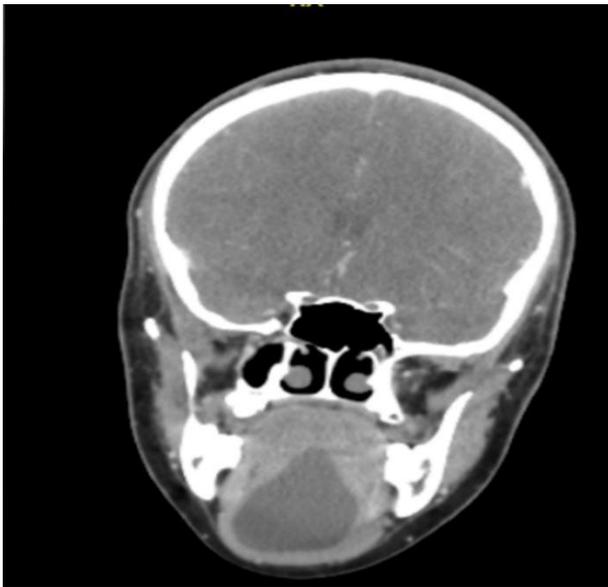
CT X-ray coronal section shows well defined radiolucent lesion located in floor of mouth, perforation the mylohyoid muscle and extended to the chine area.
